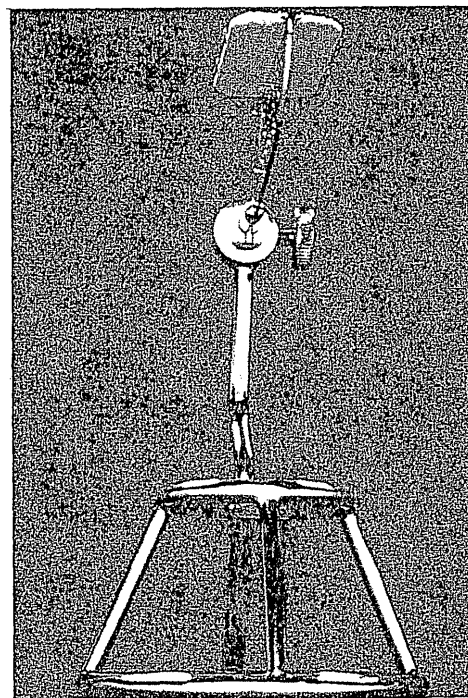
The Backer-Dirks holder to aid in the production of reproducible bitewing radiographs.
